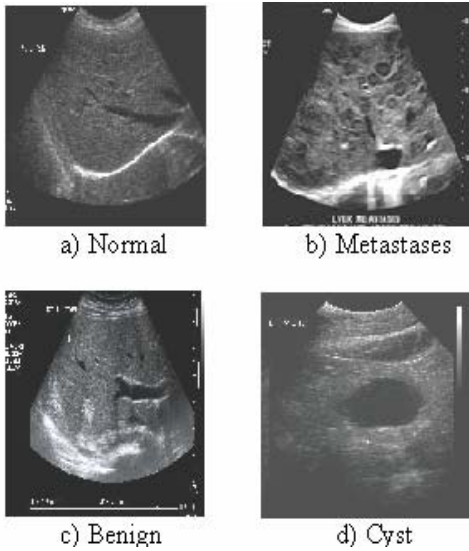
Ultrasound Liver Images Used For Analysis
